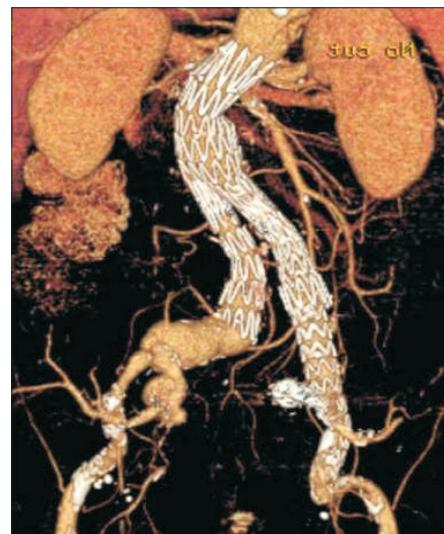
Follow-up angio-computed tomography image showing significant improvement of kinking after repair with additional stent grafts.
